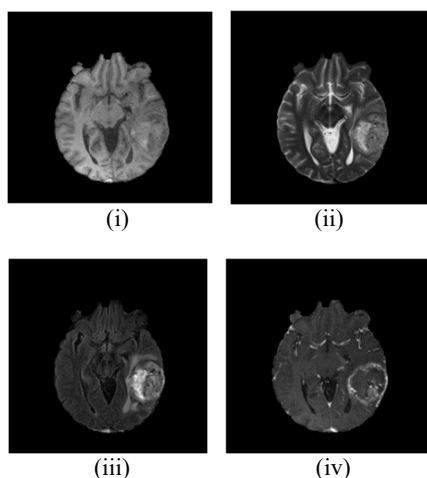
BRATS2020 MRI – Multimodal images
